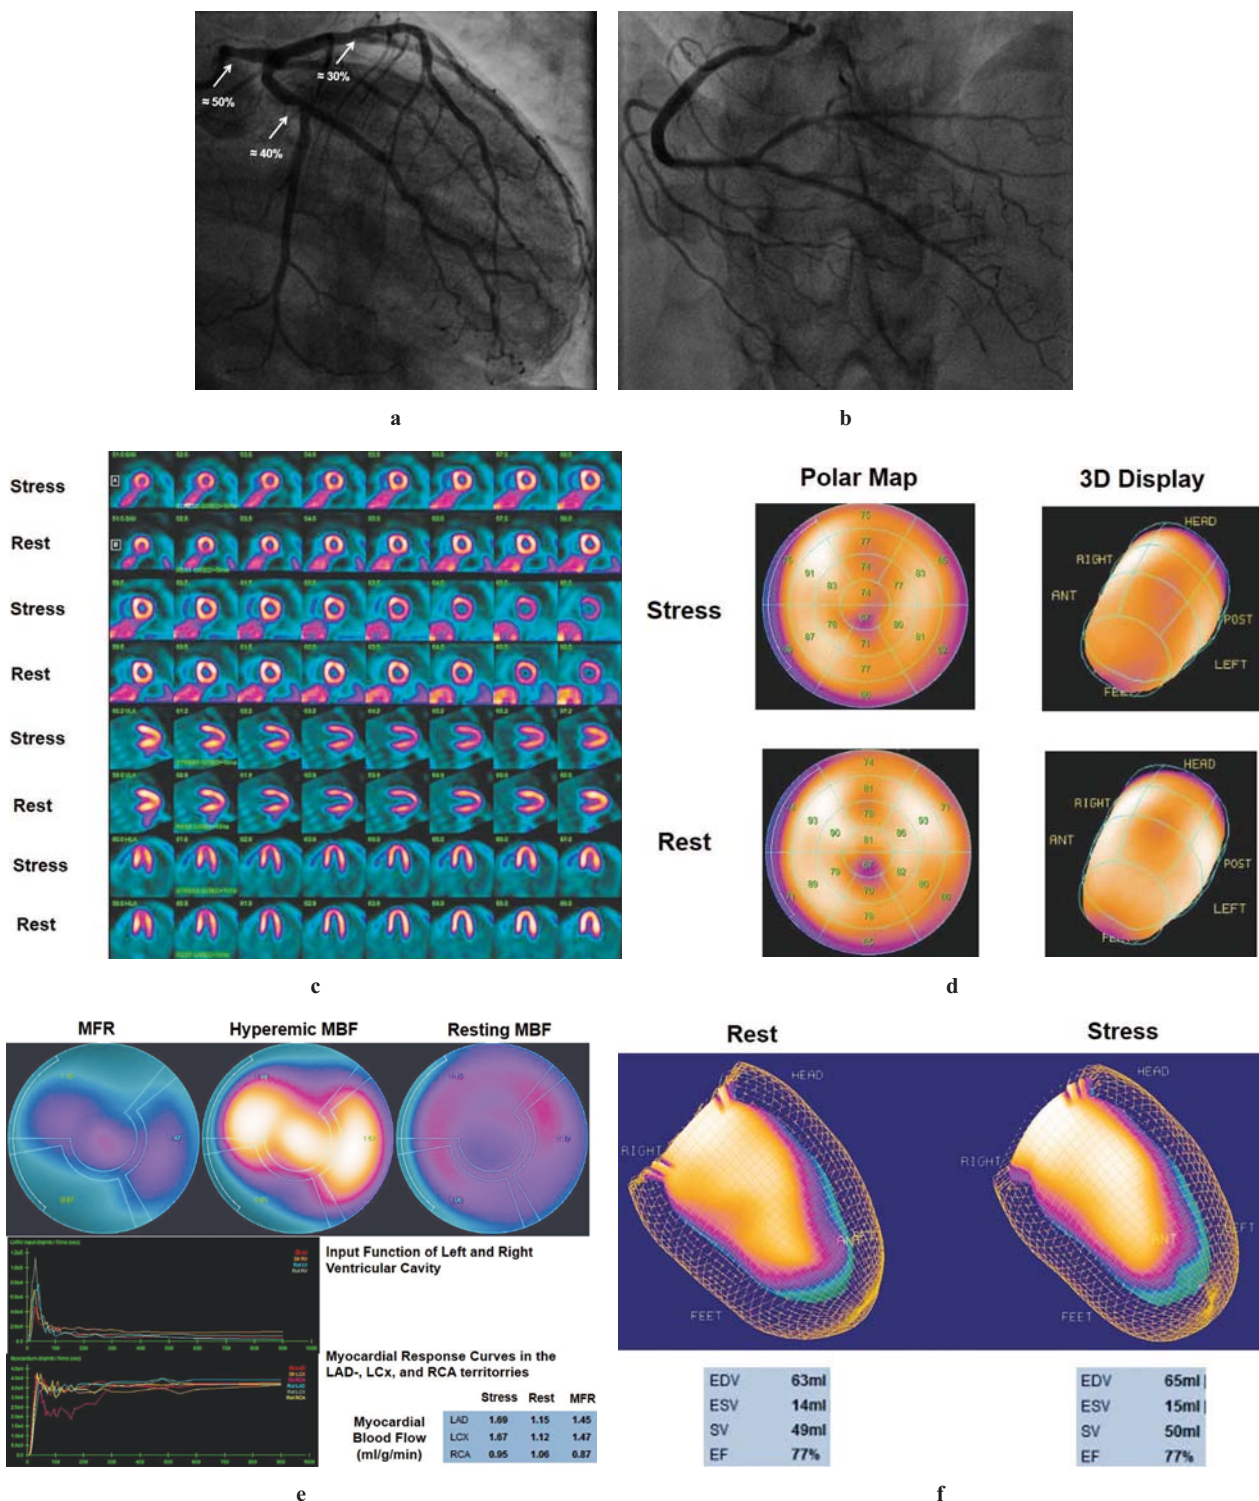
^{13}N -ammonia PET/CT-determined Perfusion, MBF, and Wall Motion with Left Main Stem Disease
